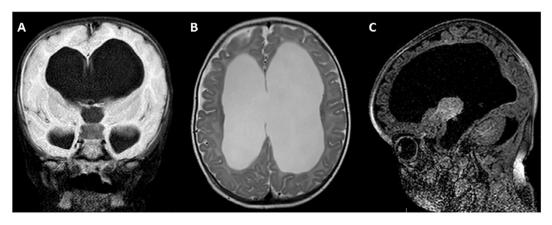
Magnetic resonance imaging showing triventricular hydrocephalus. (A) FLAIR SPIR cranial weighted coronal magnetic resonance imaging (MRI) image, (B) Axial T2 weighted MRI and (C) T1-weighted fat-suppressed sagittal cranial MRI images at age 5 months showing triventricular hydrocephalus.
